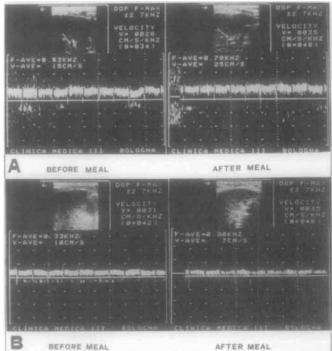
Duplex Doppler sonography of the portal vein before and after a standard meal in a normal subject (A) and in a patient with liver cirrhosis (B). Right subcostal longitudinal scans. In the normal subject, flow velocity greatly increased after the meal, whereas in the patient with liver cirrhosis, portal flow velocity frankly decreased in the postprandial state.
